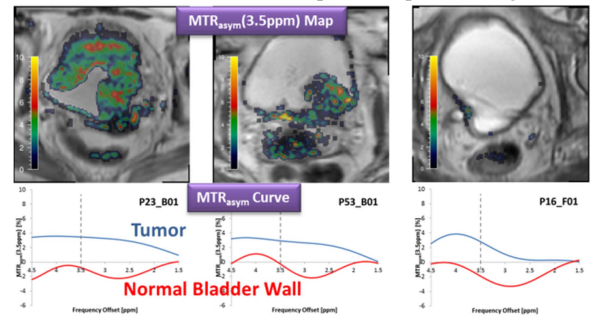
APT-MRI can depict bladder cancer region by mapping the elevated mobile protein level in cancerous tissues.
